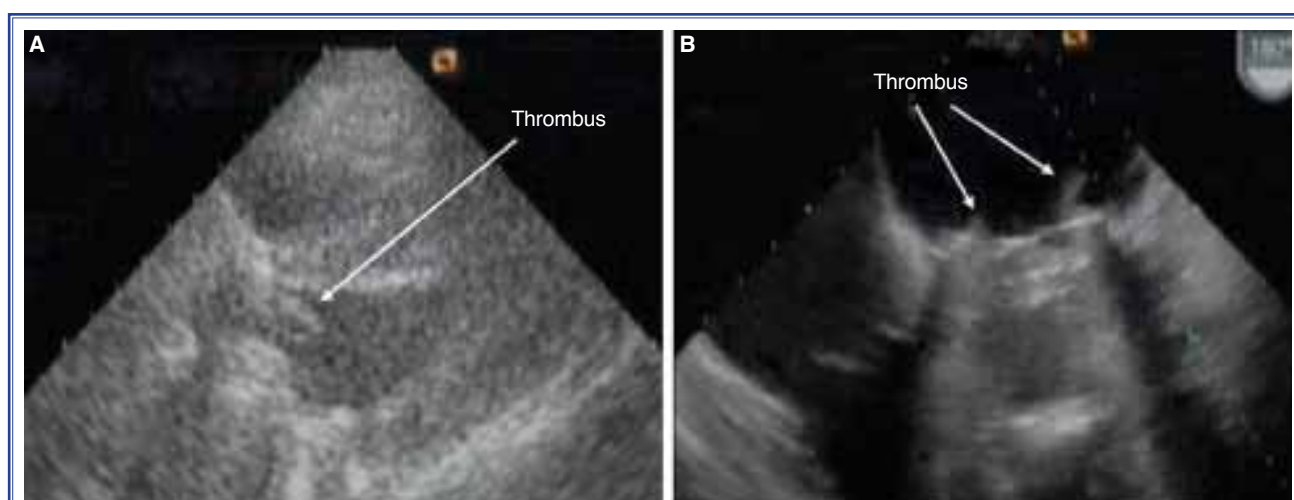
(A) The TEE view of Case 1 demonstrating multiple thrombi on the left atrial aspect of the mitral prosthesis; (B) A TTE demonstrating a fibrillar thrombus on the left ventricular aspect of the aortic prosthesis. TEE: Transesophageal echocardiography, TTE: Transthoracic echocardiography.
